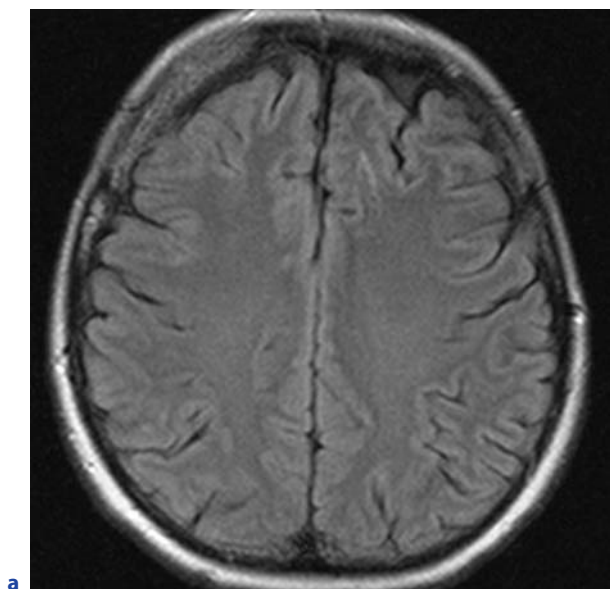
FLAIR sequence (a) with a faint tubular signal abnormality left frontal; on T1 with contrast (b) a DVA was clearly diagnosed
